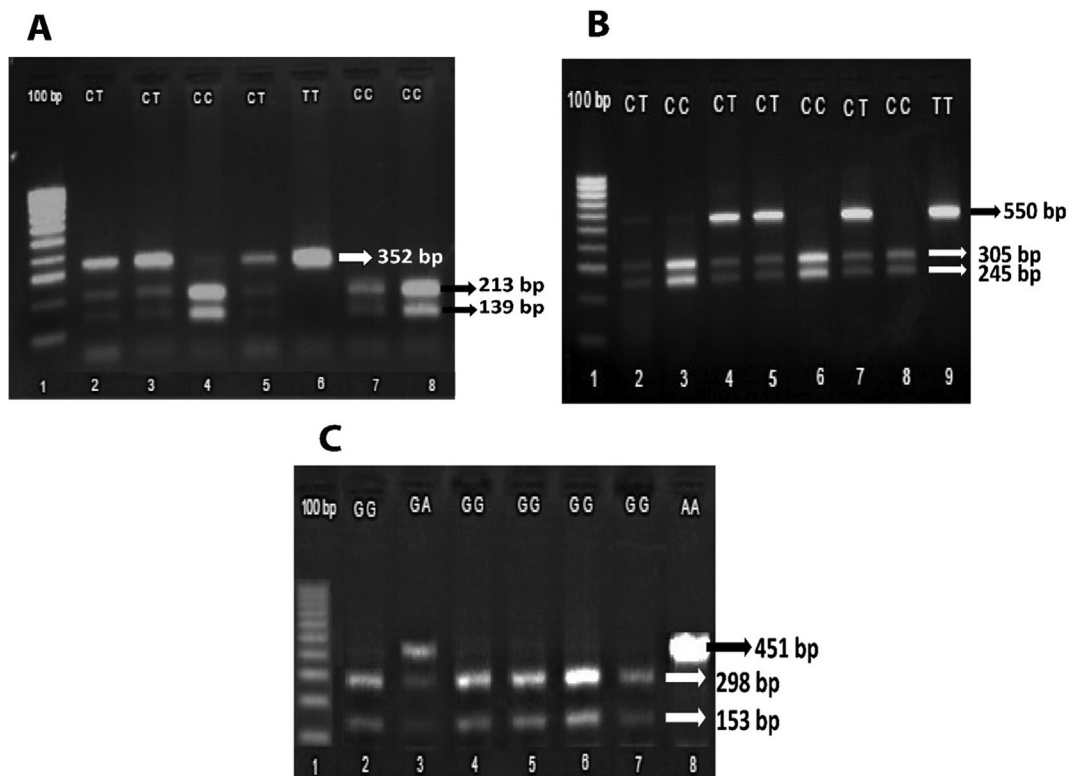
Representative 2% agarose gel electrophoresis of restriction digestion products. (A) Megalin rs2075252 polymorphism. Lane 1, a 100-bp ladder; lanes 2, 3 and 5, are a CT heterozygote with 139 bp, 213 bp and 352 bp fragments; lanes 4, 7 and 8 are a CC homozygote with 139 bp and 213 bp fragments; and lane 6 is a TT homozygote with a single 352 bp fragment. (B) Megalin rs4668123 polymorphism. Lane 1, a 100-bp ladder; lanes 2, 4, 5 and 7 are a CT heterozygote with 245 bp, 305 bp and 550 bp fragments; lanes 3, 6 and 8 are a CC homozygote with 245 bp and 305 bp fragments; and lane 9 is a TT homozygote with a single 550 bp fragment. (C) Cubilin rs1801222 polymorphism. Lane 1, a 100-bp ladder; lane 3 is a GA heterozygote with 153 bp, 298 bp and 451 bp fragments; lanes 2, 4, 5, 6 and 7 are a GG homozygote with 153 bp and 298 bp fragments; and lane 8 is a AA homozygote with a single 451 bp fragment.
